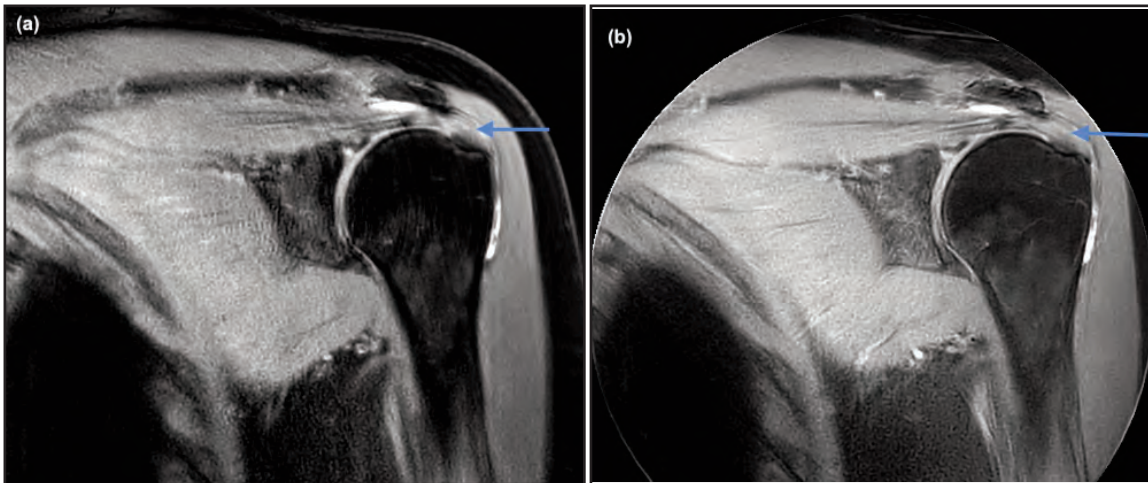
Shoulder MR images as standard coronal oblique with motion artifact (a: blue arrow) and coronal oblique PROPELLER PDFS with reduction of motion artifact (b: blue arrow)
